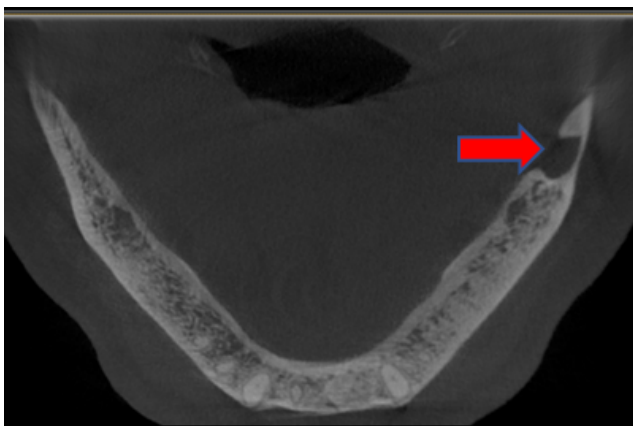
Axial section of CBCT showing radiolucency involving the lingual cortical plate of mandible.
